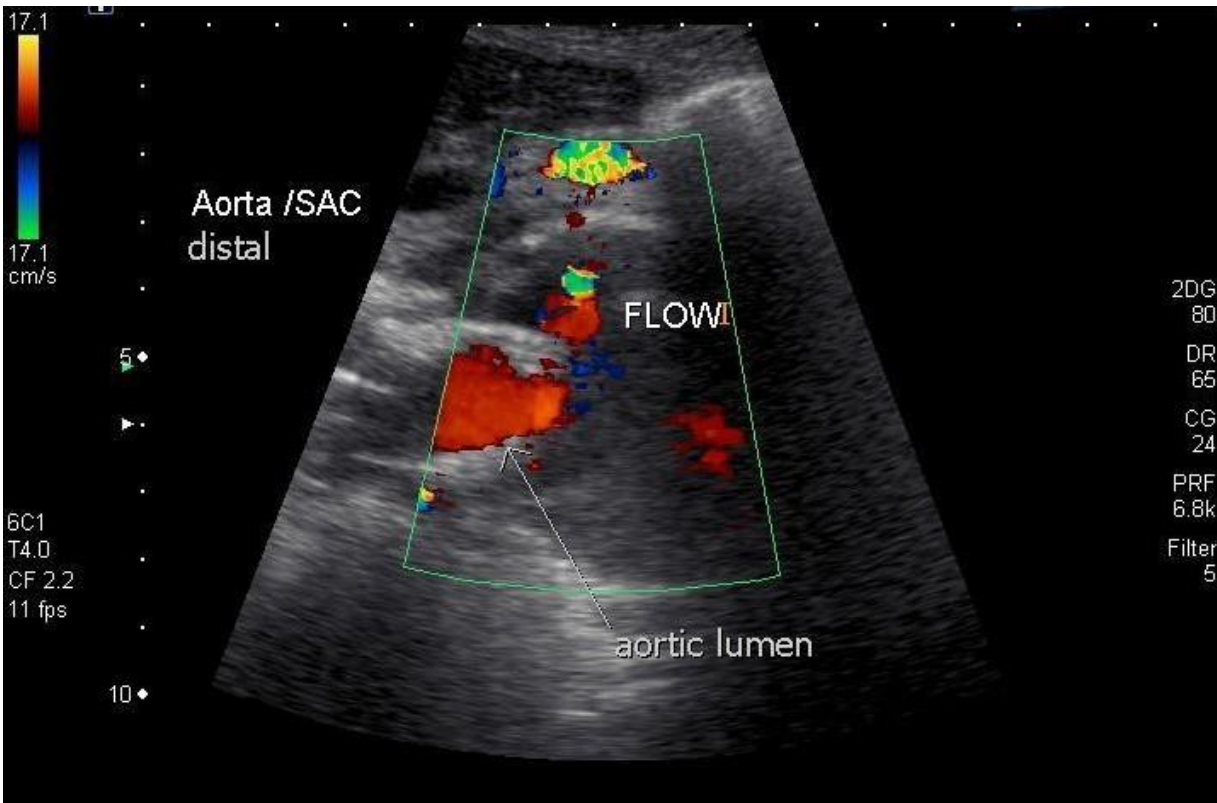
Doppler ultrasound acquisition showing a blood flow outside the SG and inside the aneurysm sac (endoleak) [160].
